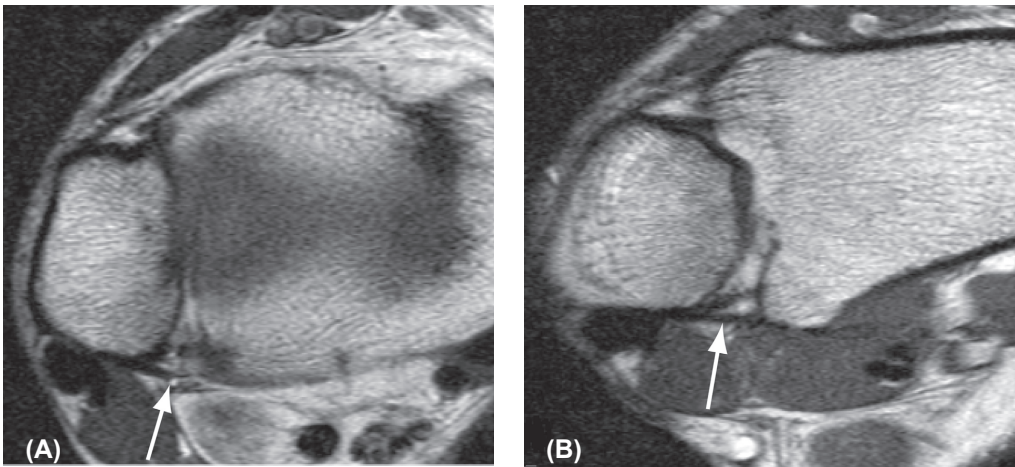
Axial (A) and oblique (B) T1-weighted TSE image of the posterior distal tibiofibular ligament (arrow) in a healthy volunteer. In the axial image (A) the discontinuous fascicles of the PTIFL are visible, whilst in the oblique image (B) the fascicles are intact. Therefore, in the oblique image plane the posterior syndesmosis is demonstrated to its better advantage.
